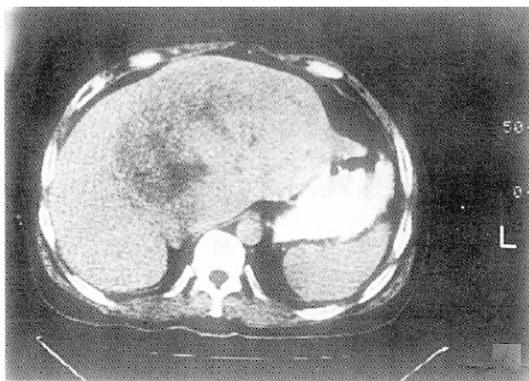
Before treatment, the computed tomography scan of the massive type of primary hepatic carcinoma showing local low density in the right and left hepatic lobar regions with 13 cm × 12 cm in size.
